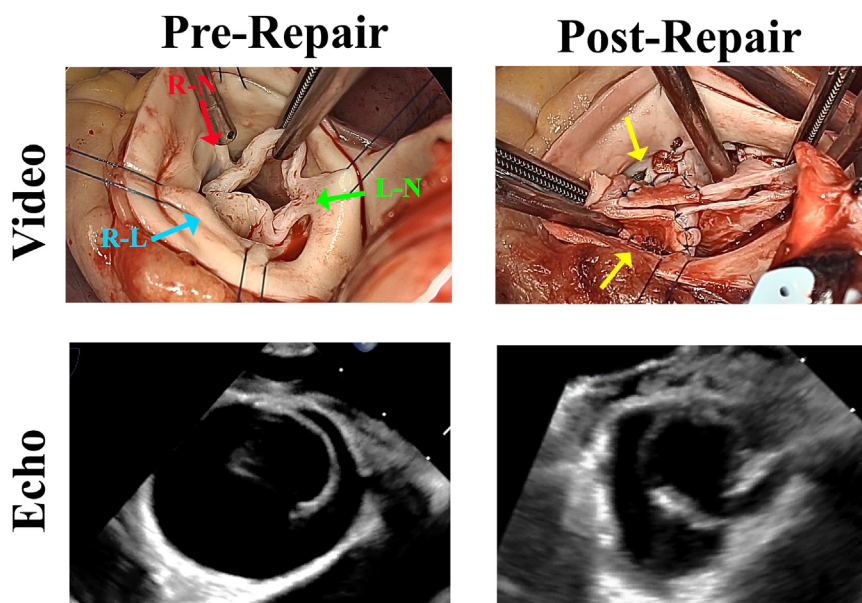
Video and echocardiograph views of a hypoplastic unicuspid valve before and after upsized repair. Red, blue, and green arrows denote the various commissures, and the yellow arrows indicate the aortic wall patches.
